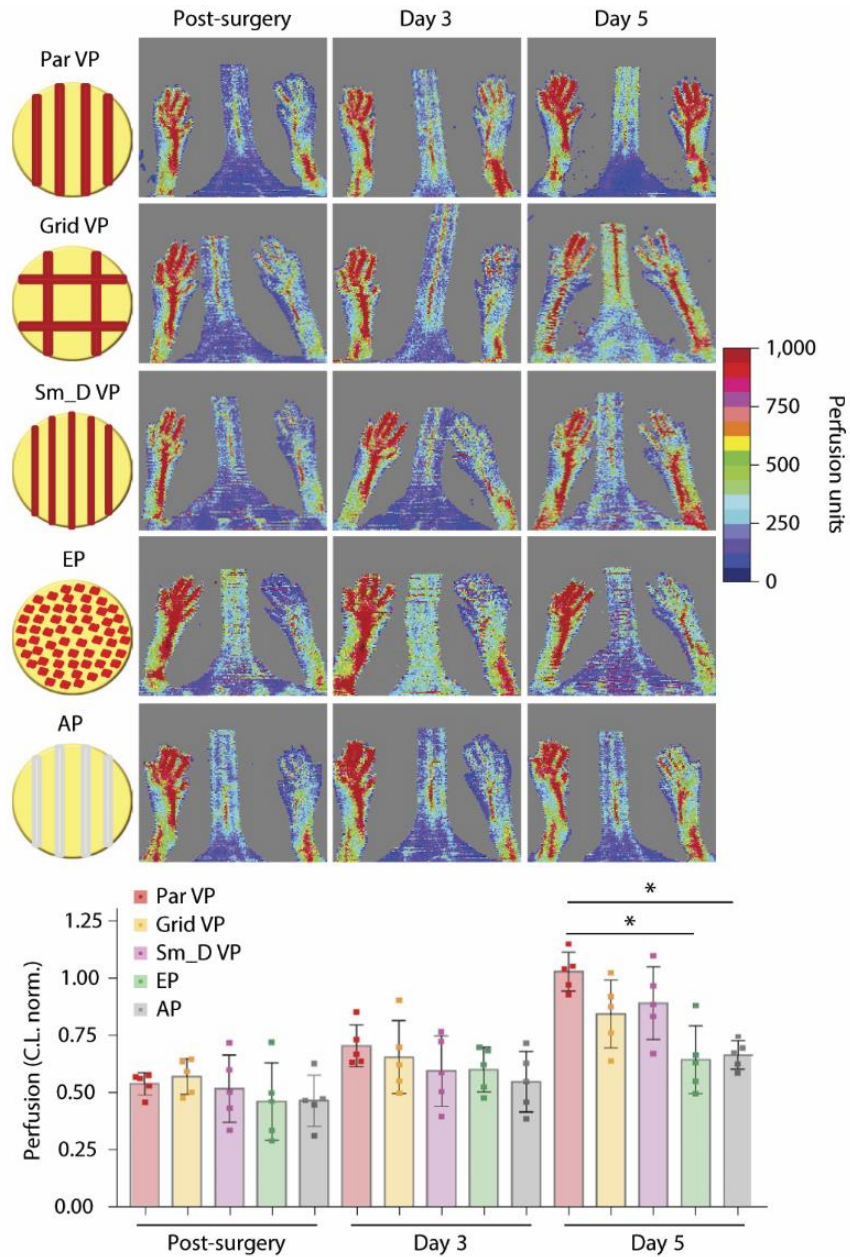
Geometric patterning within VPs impacts perfusion performance. Upper: laser Doppler imaging of distal limbs over time (post-surgery, day 3 and day 5) in the five groups: Par VP = VPs where channels were orientated parallel to each other; Grid VP = VPs where channels were orientated orthogonally to each other to form a grid; Sm_D VP = VPs with parallel channels of smaller diameter; EP = endothelial patches
